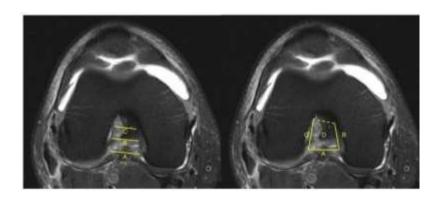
NWP and NWJ on MRI Coronal T2Fatsat. A shape – NWP < NWJ,  $\Omega$  shape – NWP > NWJ. (Ashwini)*al.*, 2018)
